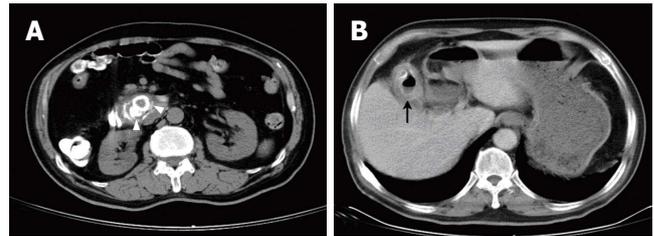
Abdominal computed tomography scan showing two round calcified stones impacting the proximal third portion of the duodenum (arrowhead) (A) and a thickened wall gallbladder with internal air and small calcified content (arrow) (B).
